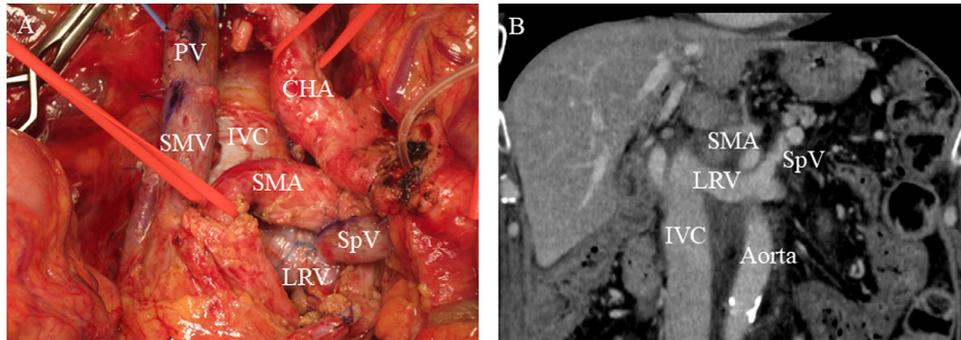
(A) Splenic vein reconstruction: after pancreaticoduodenectomy with en bloc resection of the PMSC, the PV, and SMV were anastomosed, and the splenic vein outflow was re-established with a splenorenal shunt. (B) Postoperative CT at 6 months showed a patent reconstructed splenic outflow.
